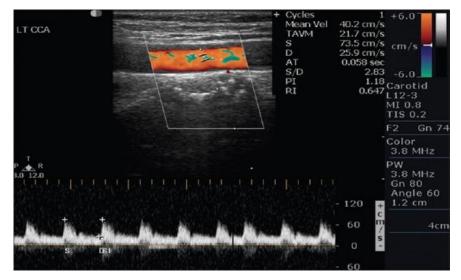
Normal Left common carotid artery color Doppler waveform in a 45-year-old male with a history of transient ischemic attack and normal brain computed tomography scan study ⁽²⁴⁾
